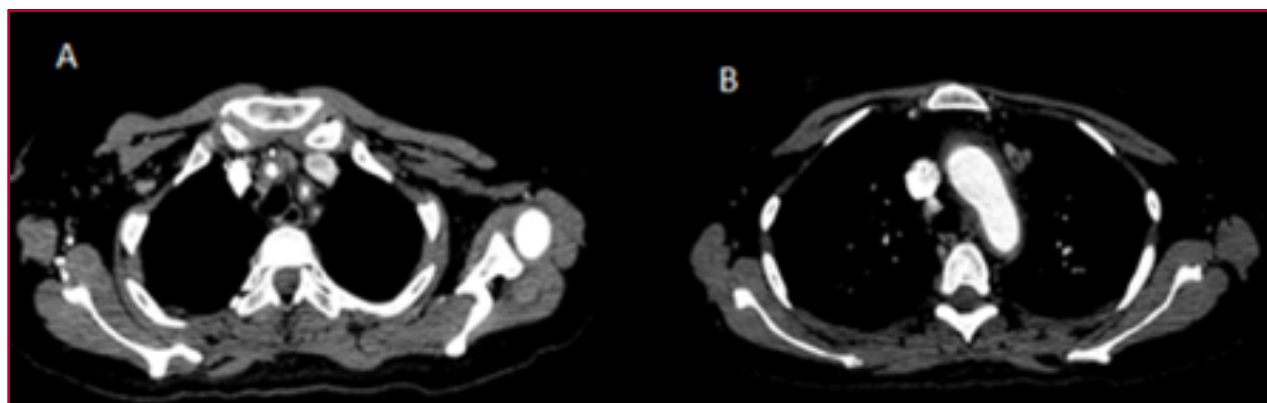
A. Computed tomography angiography (axial section), showing mural thickening at the level of the origin of the left subclavian artery, left carotid artery and right brachiocephalic artery. B. Computed tomography angiography (axial section), showing mural thickening of the aortic arch.
